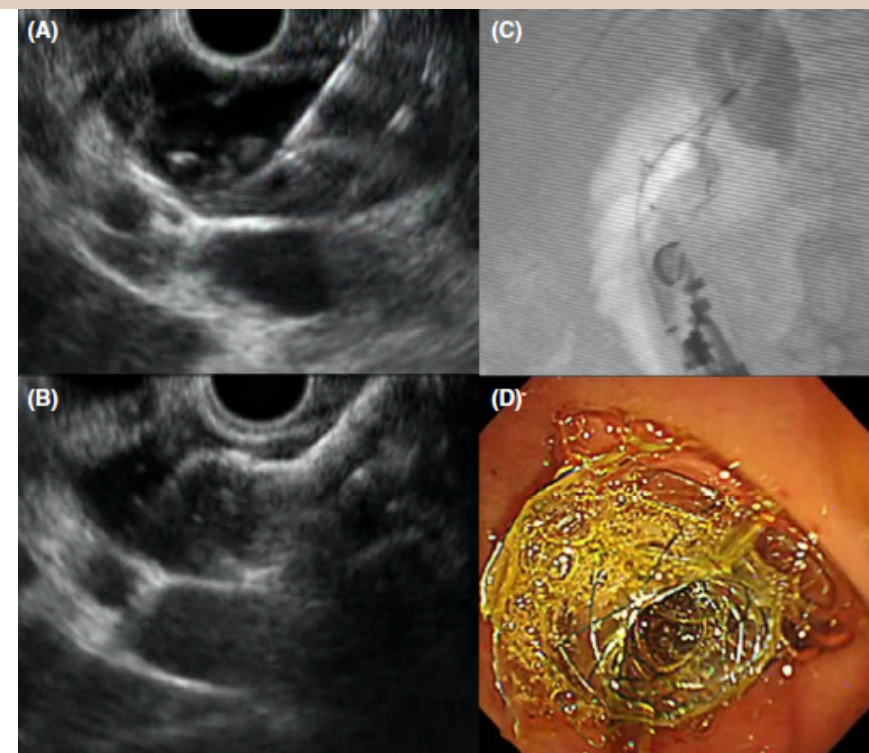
Endoscopic ultrasound (EUS) guided-choledochoduodenostomy (CDS) with self-approximating lumen apposing metallic stent (S-LAMS). (A) A 19-gauge needle was used to puncture the CBD. (B) EUS-guidance was used for monitoring the deployment of the distal flange. (C) Fluoroscopic view of after deployment of the distal flange. (D) Endoscopic view after complete deployment.
